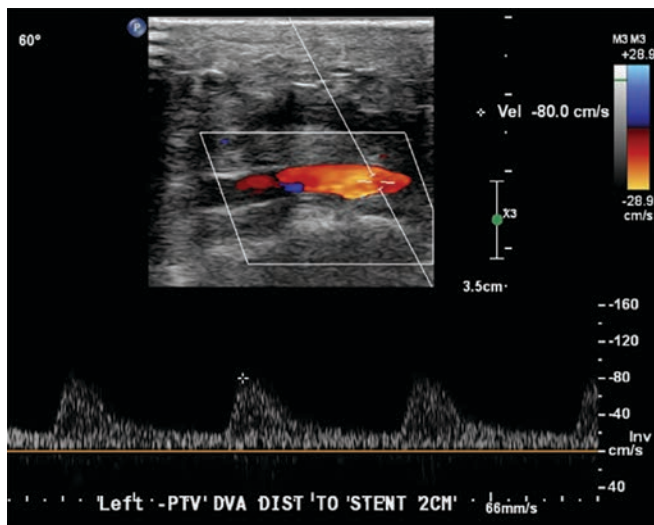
Duplex ultrasound images for 6-month follow-up visit demonstrating a pulsatile waveform and a functional transcatheter arterialization of the deep veins.
